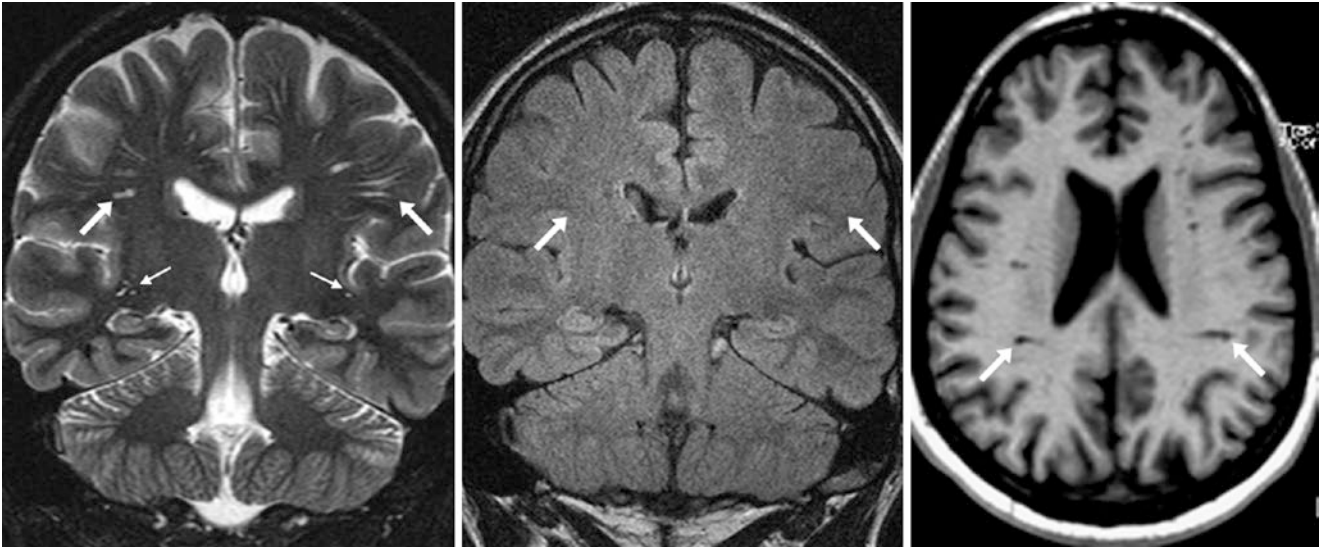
A 35 year old had dilated PVSs within the posterior frontal and anterior parietal white matter bilaterally (*arrows*). They appear radiating and ovoid and are hyperintense on coronal T2WI (*left*), suppress on FLAIR (*middle*), and are nearly as dark as CSF on T1WI (*right*). Tiny PVSs are also noted within the temporal stems (*tiny arrows*)
